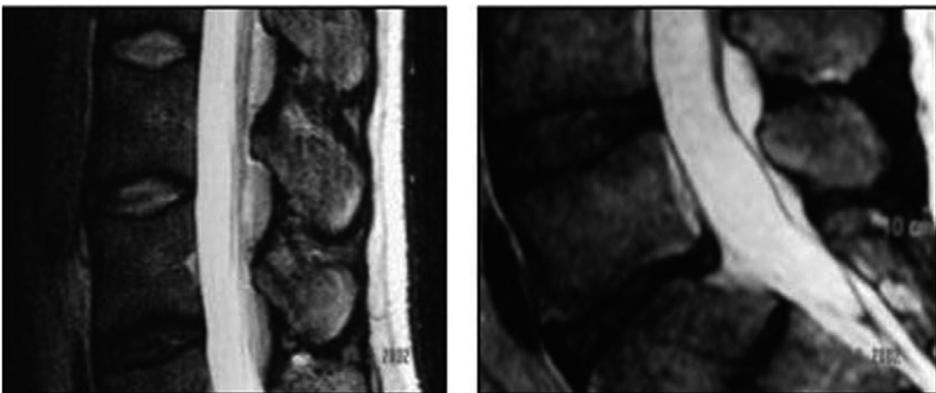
Degenerative morphological changes (2a) and a prolapse of an intervertebral disc (2b) shown by MRI in women with breast hypertrophy.
